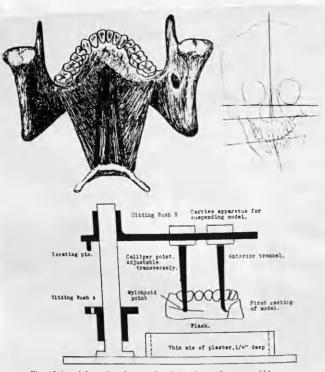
(top left).—Attachment of mylohyoid muscle to mandible. Fig. 96 (top right).—Tracing of frontal cophalometric x-ray demonstrating ha of parallelism of mandible with line drawn across lower edges of orbits. Fig. 97 (bottom).—Method of suspending first easting of orthodontic model aof furnishing lower model with a base parallel to mylohyoid line. (Courtesy of Campbell, J.: D. Rec. 70:204-208, Sept. Oct., 1950.)
